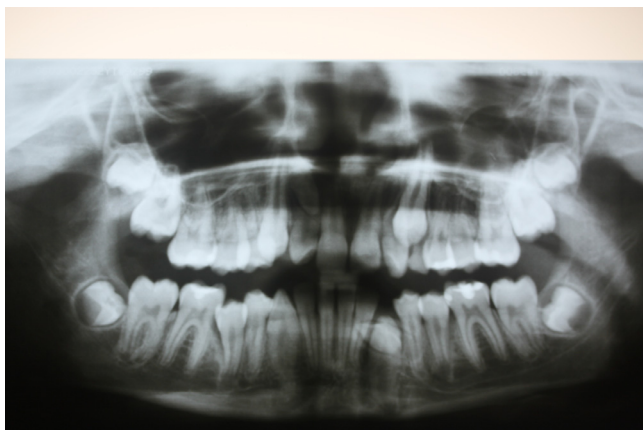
Panoramic x-ray: supernumerary teeth (in the region of 11-12 and 33). In the picture, there are also impacted teeth 23 and 33 and pulp stones in molars.
